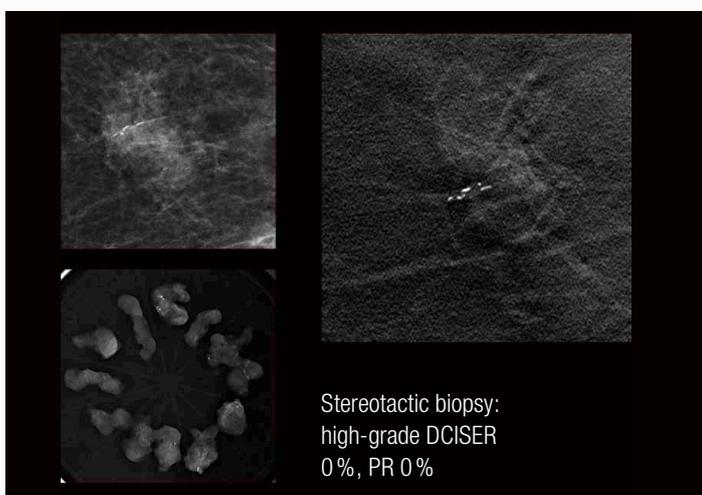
Tissue sample radiography after stereotactic biopsy and surgery planning with digital mammography
